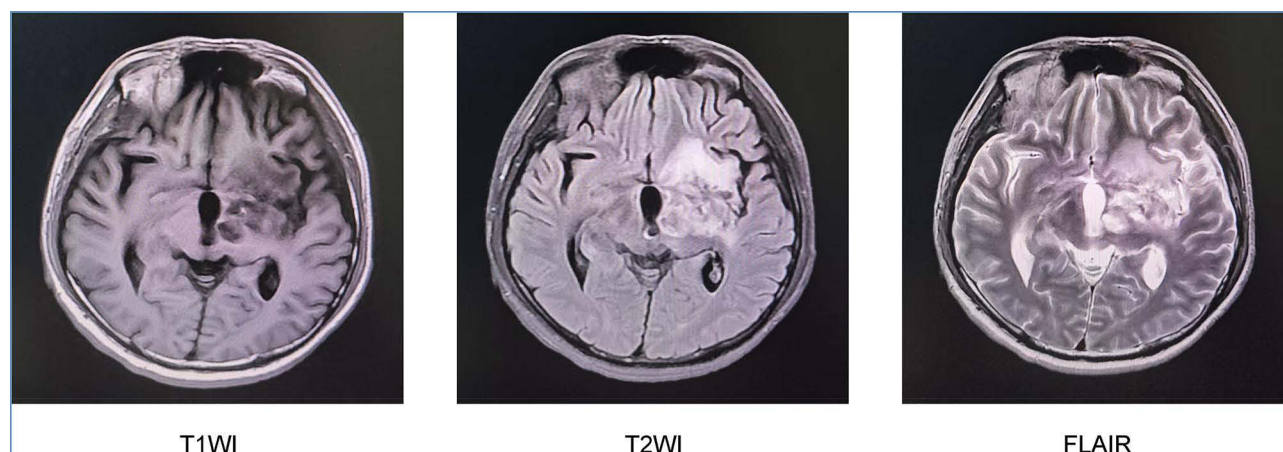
T1WI, T2WI and FLAIR axial views of the patient's cranial MRI on June 13, 2025.
